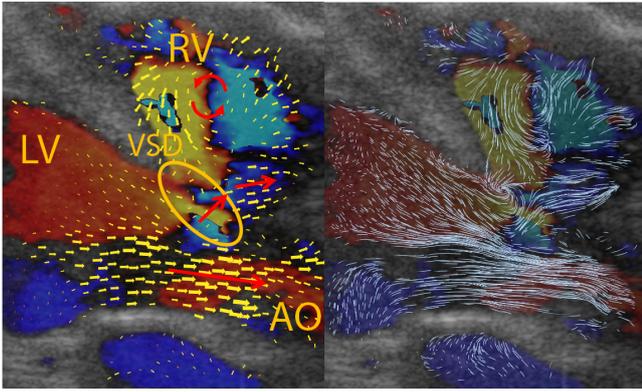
An instant of the systolic phase in a ventricular septal defect (VSD) patient. Visualized using color Doppler and arrow plots (left) and using pathlets (right). Pathlets help conveying the shunt flow going through the septum and the vortex in the right ventricle.
